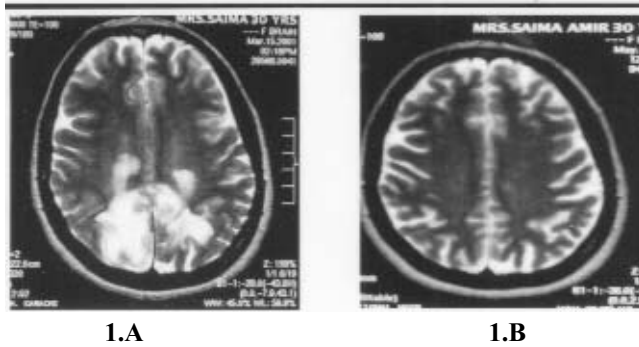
A. Axial T2-weighted MR image demonstrates abnormal high intensity signals in bilateral parieto-occipital region. B. Follow up scan shows that all radiological abnormalities have completely resolved.
